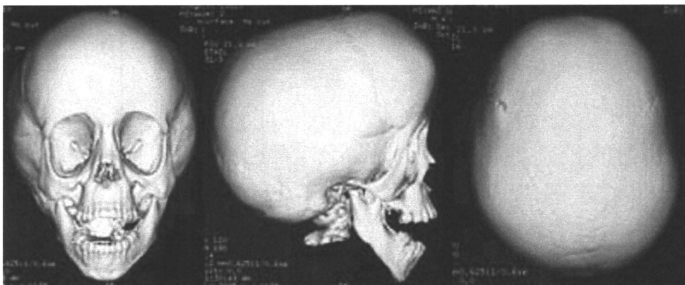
Craniofacial 3D CT image.
